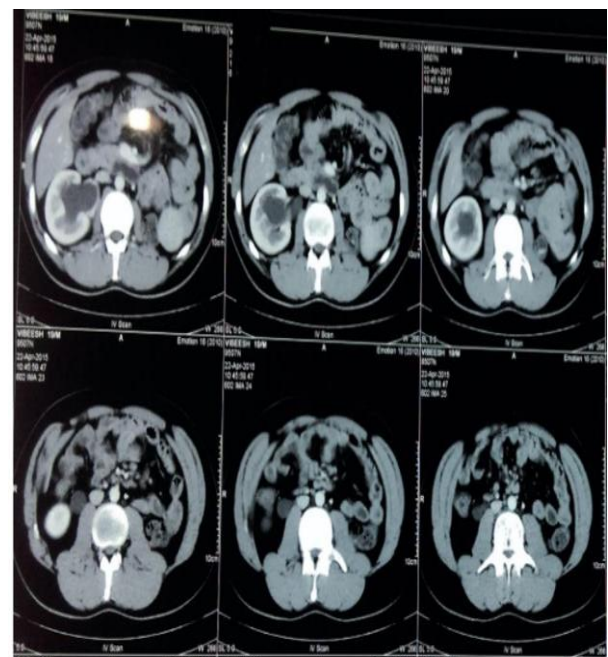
CT scan image showing right hydronephrosis and hydroureter upto level L3 where the ureter crosses behind the IVC, along with left renal agenesis.
